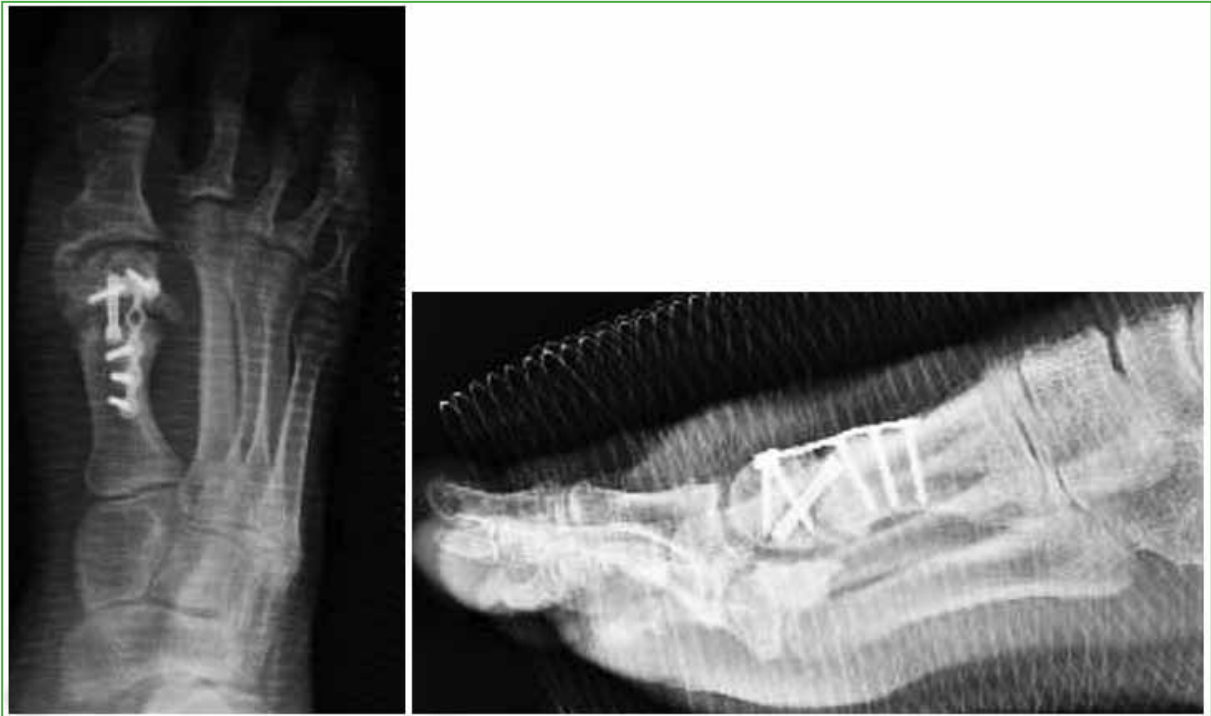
Anteroposterior and lateral radiographs of the foot, three months after the operation. A nonunion focus is observed at the level of the chevron osteotomy.
